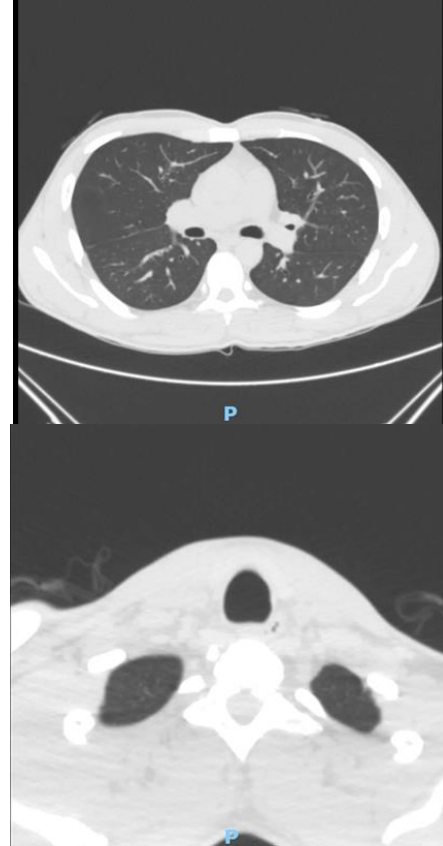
Post resolution Thoracic CT scan images.
